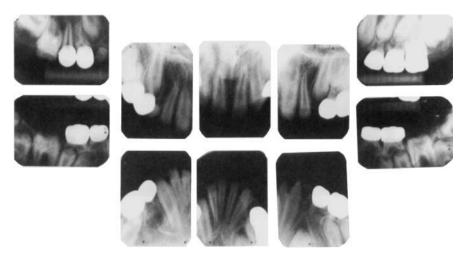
Radiographs of P.M. at 12 years show a full complement of permanent teeth but with marked delay in eruption of the permanent premolar and molar teeth. The left permanent first molar is the only tooth in occlusion other than the incisors.
